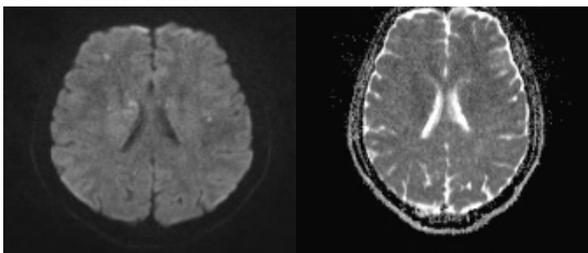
DW images show lesions in right frontal gray-white matter junction & caudate nucleus which appear hyperintense on DWI with decreased ADC; they represent cytotoxic edema presumably due to the leakage of glutamate from the axon.
